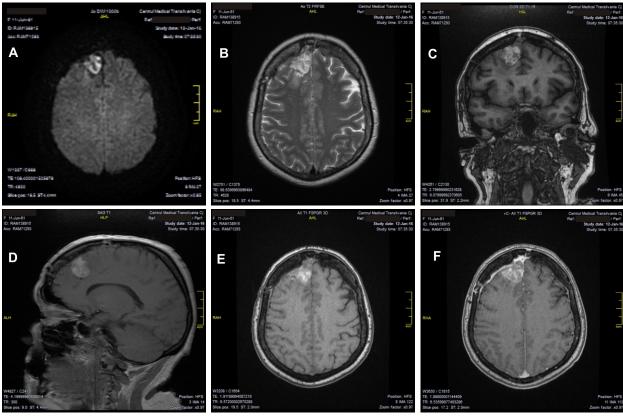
MRI analysis: (A) Axial diffusion; (B) Axial T2; (C) Coronal T1; (D) Sagittal T1; (E) Axial T1; (F) Axial T1 with contrast enhancement.
